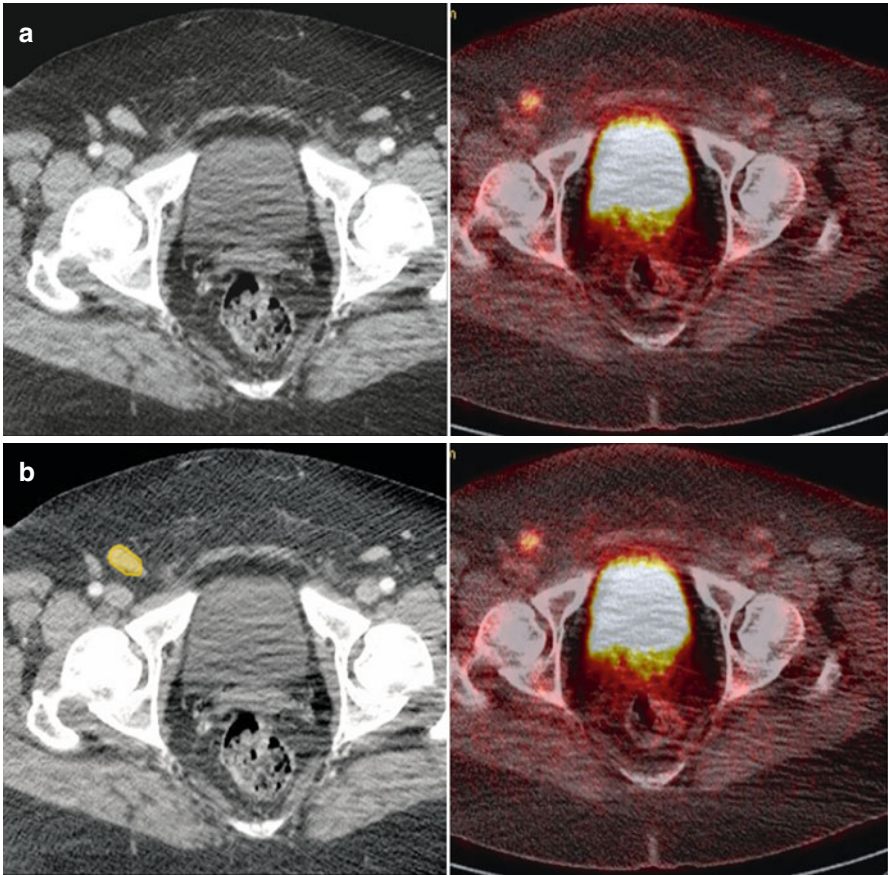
(a, b) Axial CT and PET-CT–fused images show FDG avid right inguinal lymph node (*orange*) in a patient with vulvar cancer
